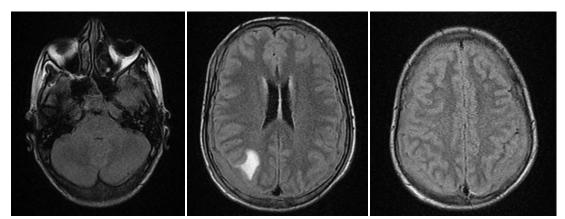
Image showing sections of the brain MRI, FLAIR sequence, in the axial plane showing the thickening of the meninges in iso-signal
